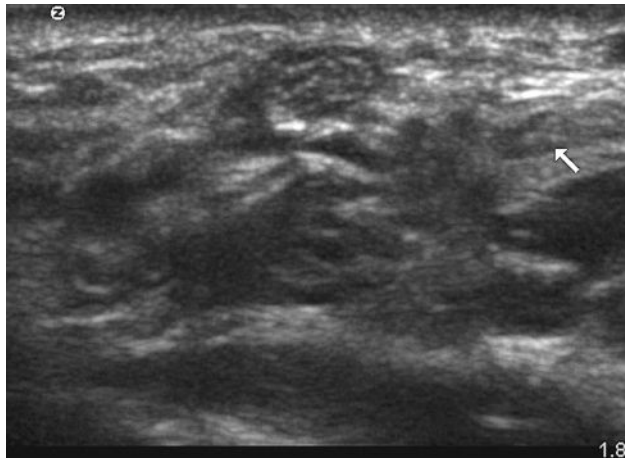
Immediate post-injury ultrasound depicting avulsion and retraction of the distal biceps tendon (arrow).
